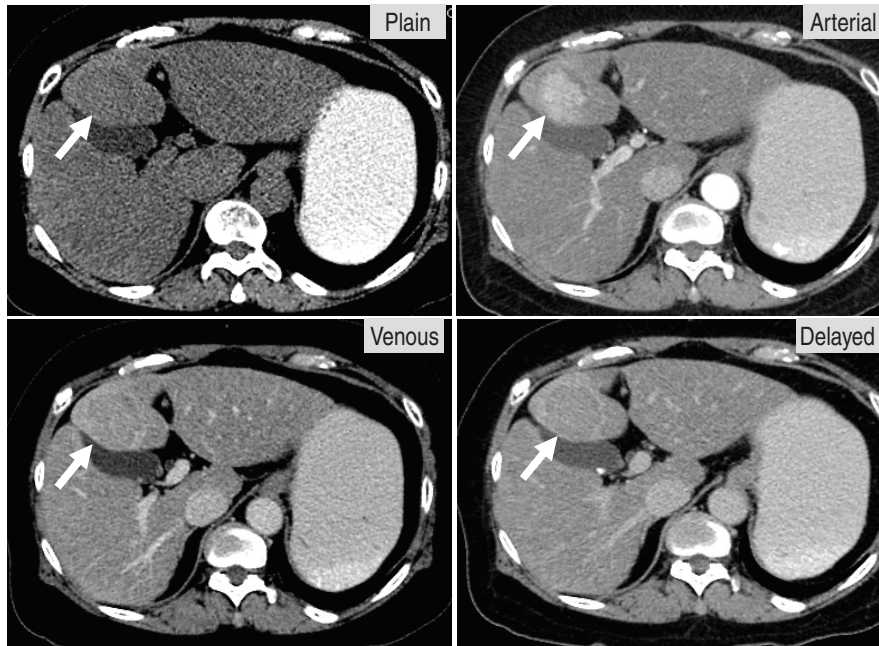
Multiphase multislice CT shows arterial enhancement, venous and delayed washout, characteristic for HCC.
